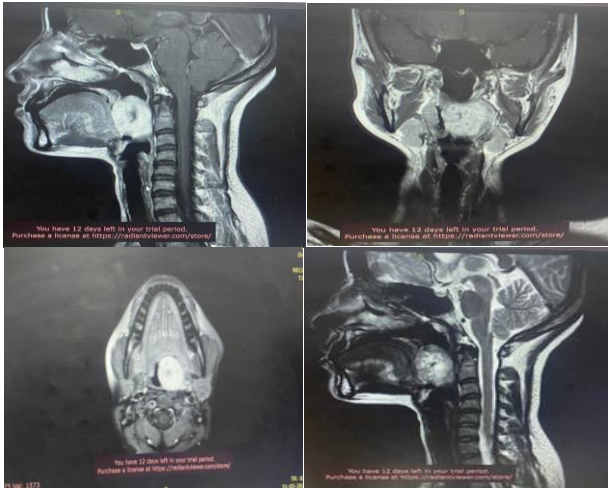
Contrast-enhanced magnetic resonance imaging neck revealed a left tonsillar fossa mass with loss of fat planes with the left medial pterygoid, left lateral wall of the oropharynx, and left longus colli muscle.
